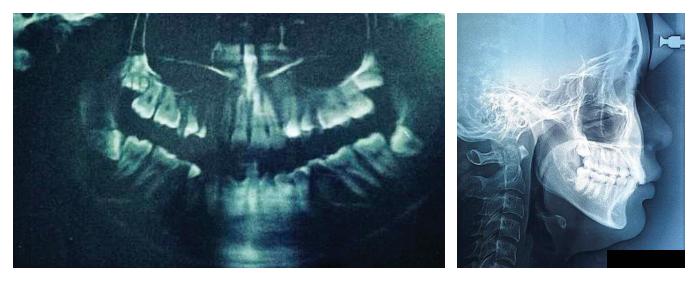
Patient's pre-treatment orthopantomogram and cephalogram.
